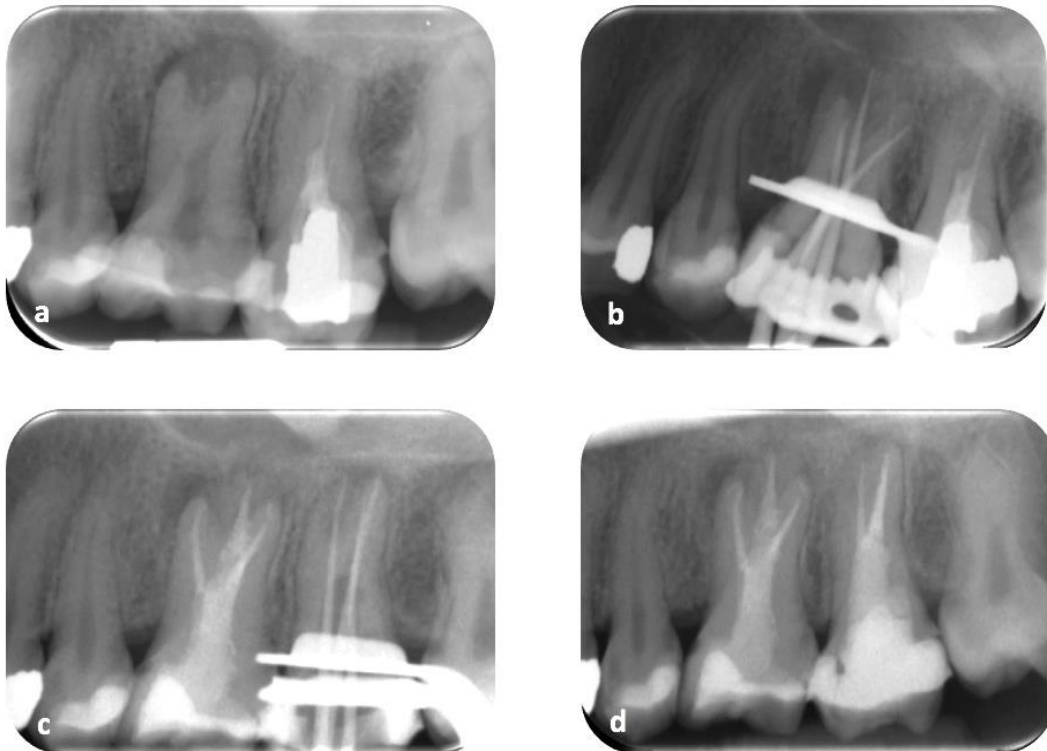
PA radiographs of tooth 26 and 27 (a) Pre-operative (b) Master cone 36 (c) Master cone 27 (d) Postoperative.
